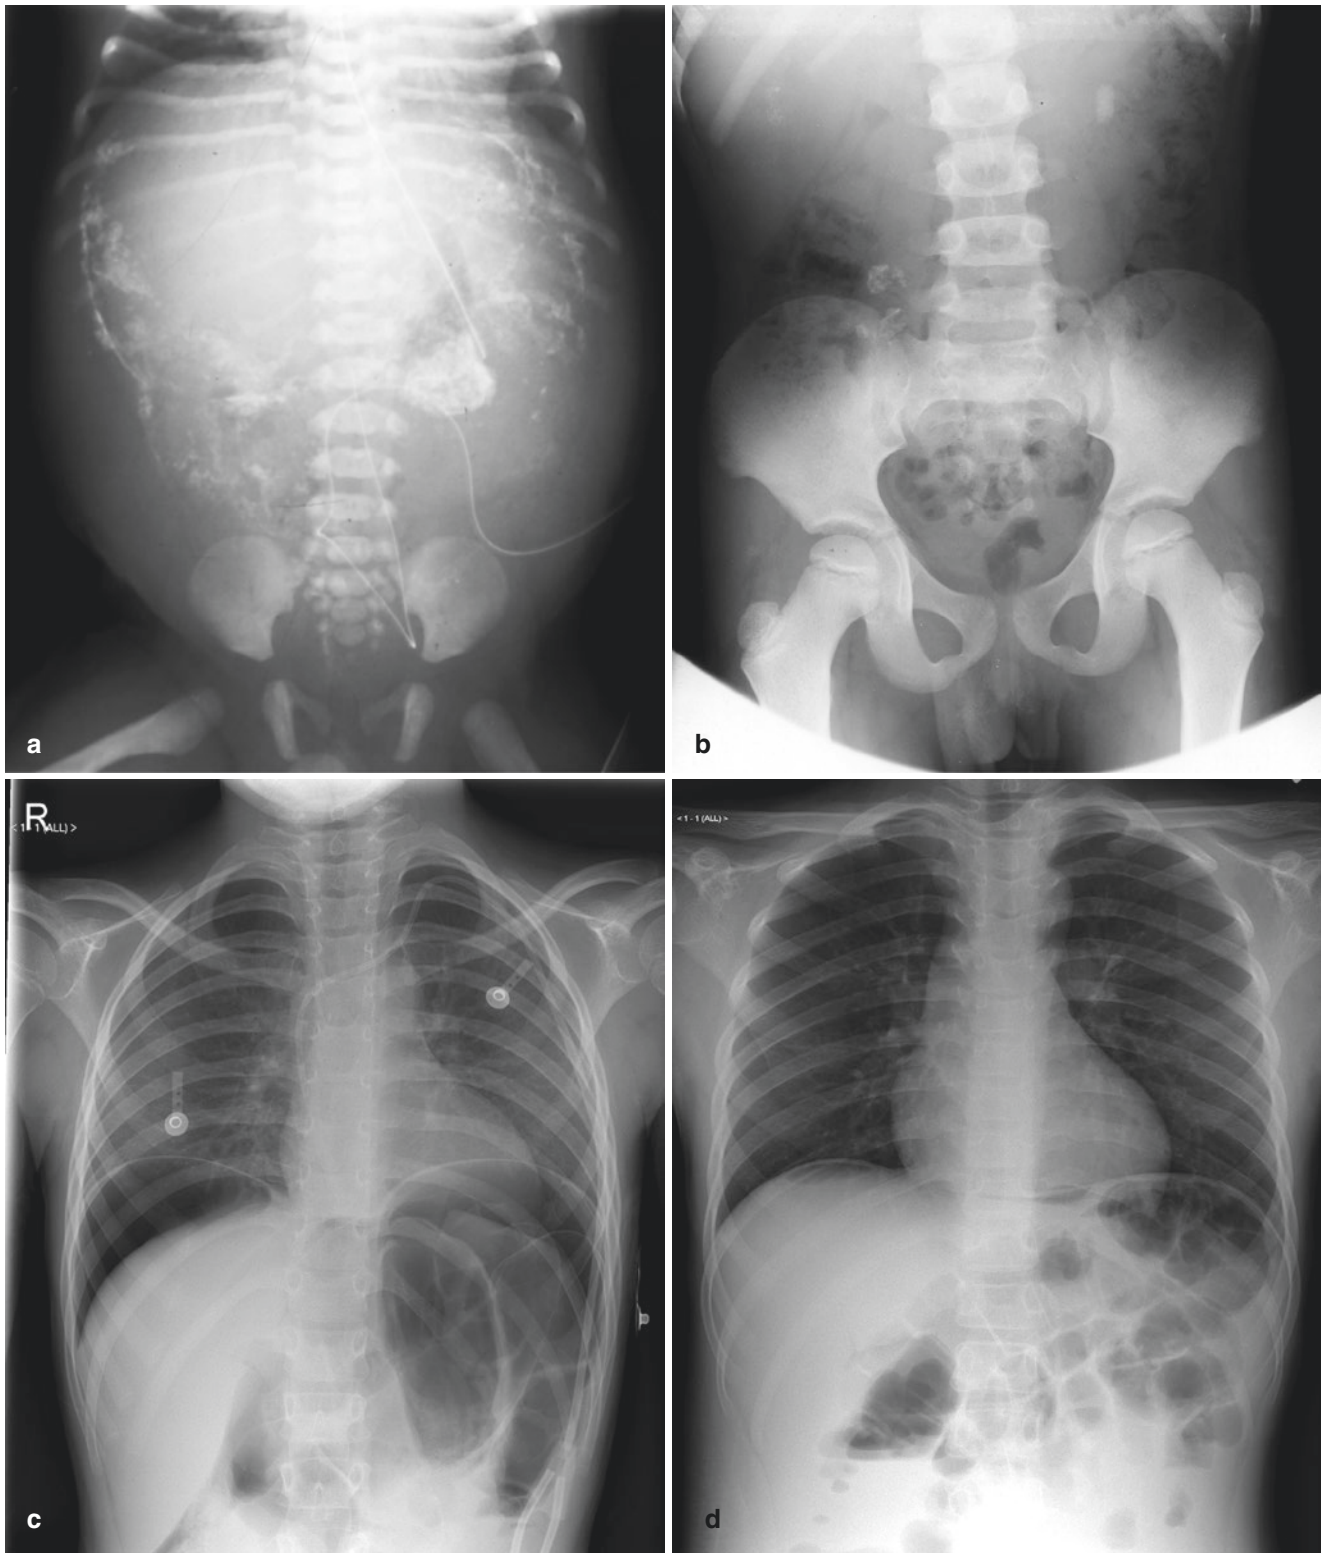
(a) Intraperitoneal calcification. Plain X-ray showing extensive widespread intraperitoneal calcification from an intrauterine perforation. (b) Calcified mesenteric glands on a plain X-ray of the abdomen from tuberculosis. (c) Pneumoperitoneum. Free gas is seen on this plain X-ray with a lot of air under both diaphragms. A Hickman central line
